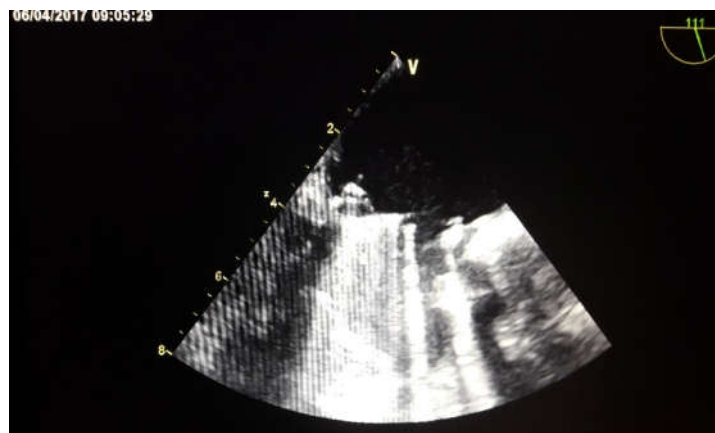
Transoesophageal echocardiography: stuck mitral valve and pedunculated thrombus
